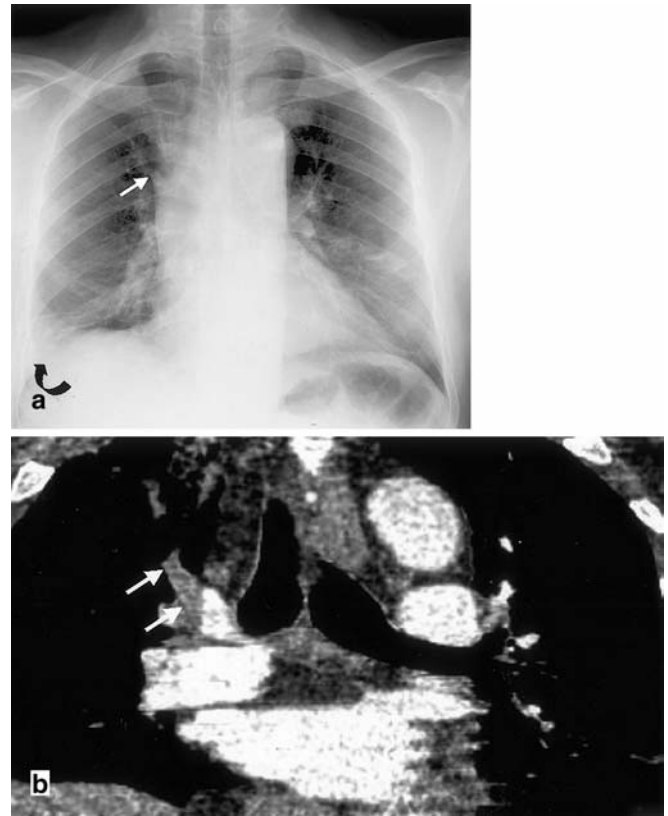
A 45-year-old man with right thoracic pain, dyspnea, and hemoptysis. a Frontal chest X-ray does not reveal any parenchymal abnormalities. Right pleural effusion is present (*curved arrow*). The right upper lobe artery appears enlarged in its initial portion (Fleischner's sign) and then amputated (knuckle sign; *straight arrow*). b Magnified view of the coronal reconstruction image obtained at the level of the right upper lobe artery with multislice CT (soft-tissue window settings, 1.3 mm collimation, 0.6 mm interval reconstruction) reveals complete vascular occlusion of the right upper lobe artery (*straight arrows*), just after its origin
